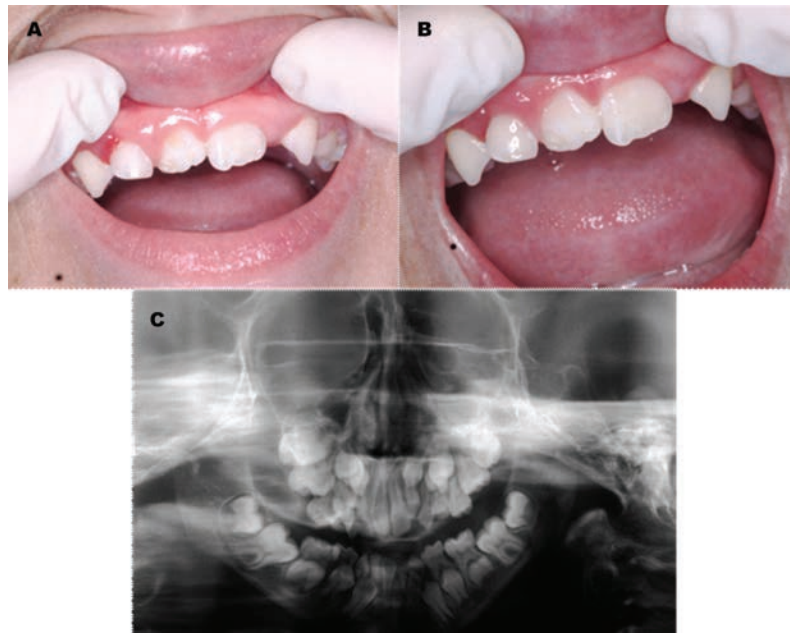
A) Intraoral examination at 8 years of age. B) Clinical evolution after oral hygiene counselling. C) New panoramic radiograph after 2 years, confirming presence of all germs of permanent successors.
